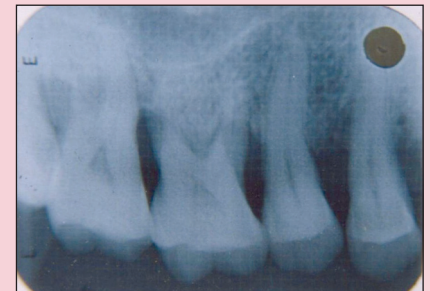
Postoperative radiograph of the control defect at 6 months.
